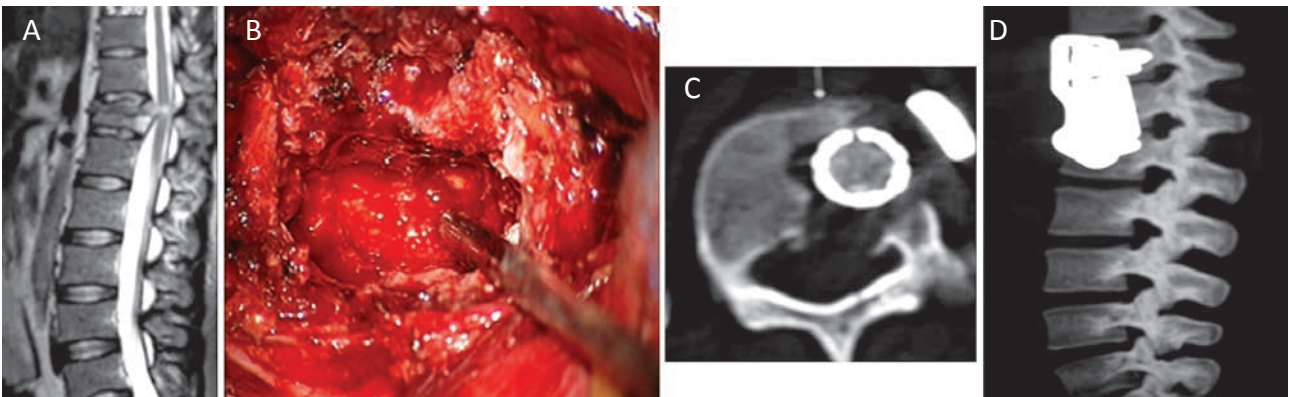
A: Preoperative Sagittal MRI showing DV12 fracture with retropulsed fragment. B: operative foto after corpectomy. C: axial CT-scan showing good decompression. D: sagittal CT-scan reformate after plating.
